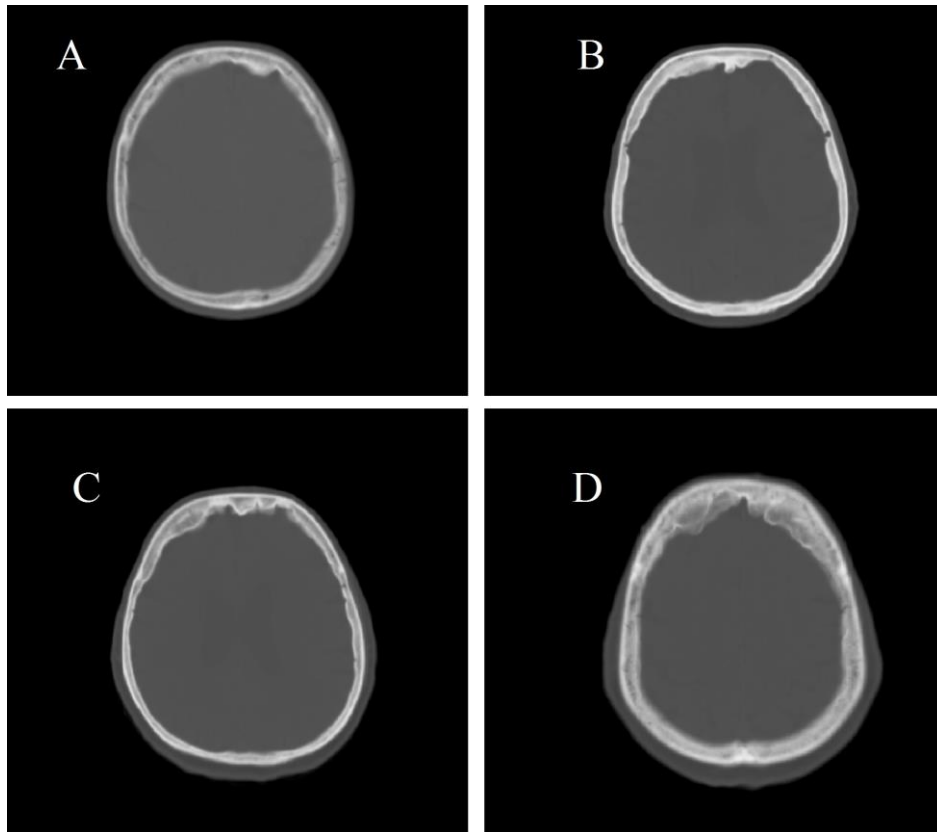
Representative transversal slice of the head CT of patients with different types of HFI (A, B, C and D)
